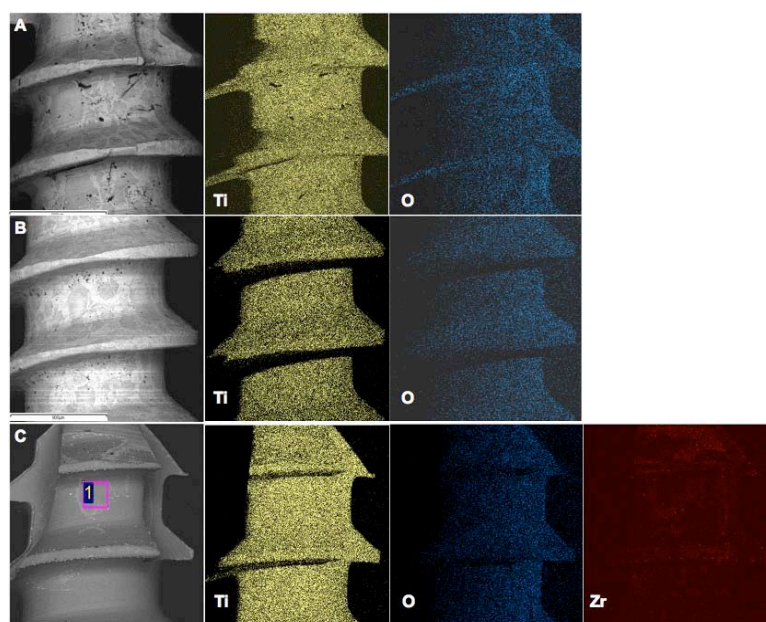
X-ray microanalysis (EDX) of the Titanium and Zirconium oxide coated implants. A, B and C- SEM image of the implants. Ti, O and Zr - Scanning of the surface demonstrate the presence of titanium (Ti), oxygen (O) and zirconium (Zr) on the surfaces.
